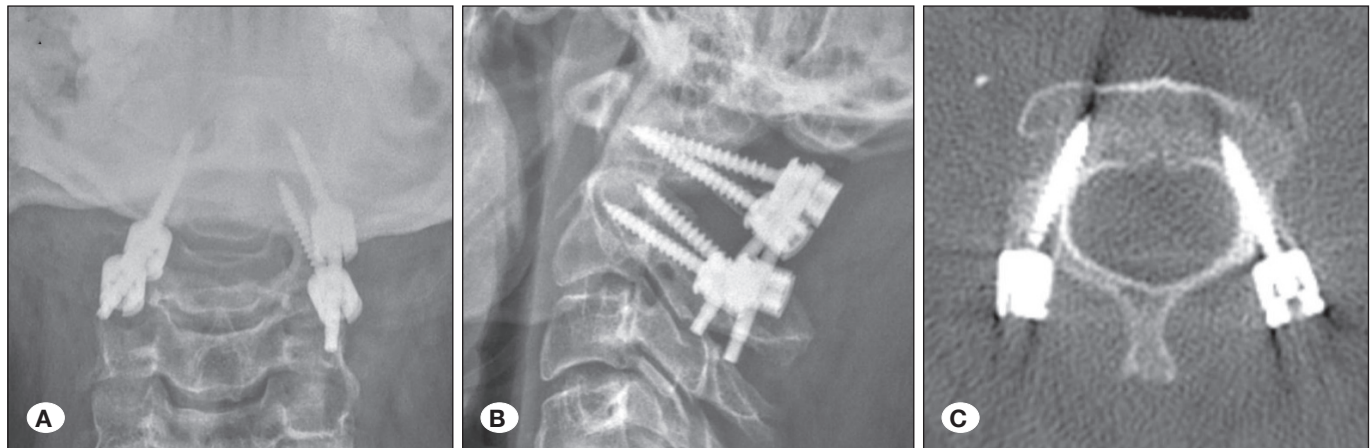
Posterior C1–C2 fixation in basilar invagination associated with Chiari malformation. A 31-year-old female underwent posterior fossa decompression with duraplasty and C1–C2 fixation. A) Postoperative anteroposterior radiograph. B) Lateral radiograph. C) Axial computed tomography confirming bilateral C2 pedicle screw positioning.
